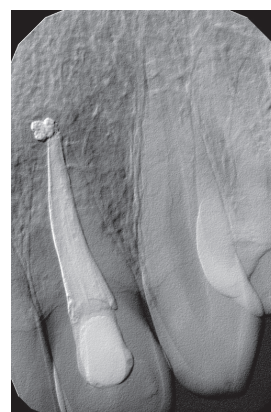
X-ray after 8 years after root canal treatment
